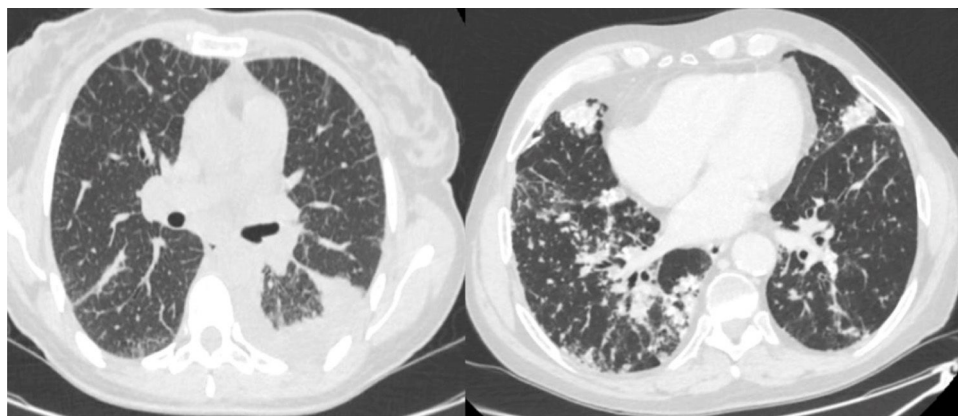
On the left (a), computed tomography from the first case showing diffuse bilateral septal interstitial infiltrates with extensive alveolar consolidation in the left lower lobe and lingula. On the right (b), computed tomography from the second case showing bilateral infiltrates.
